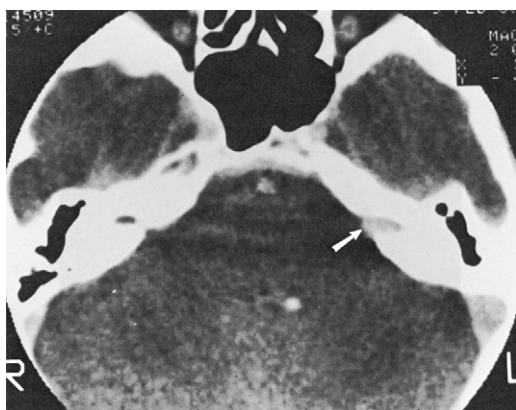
Small acoustic neuroma on enhanced computed tomography. The edge of the tumor (*arrow*) is clearly seen. Compare the density within the canal with the cerebrospinal fluid density in the opposite canal.
